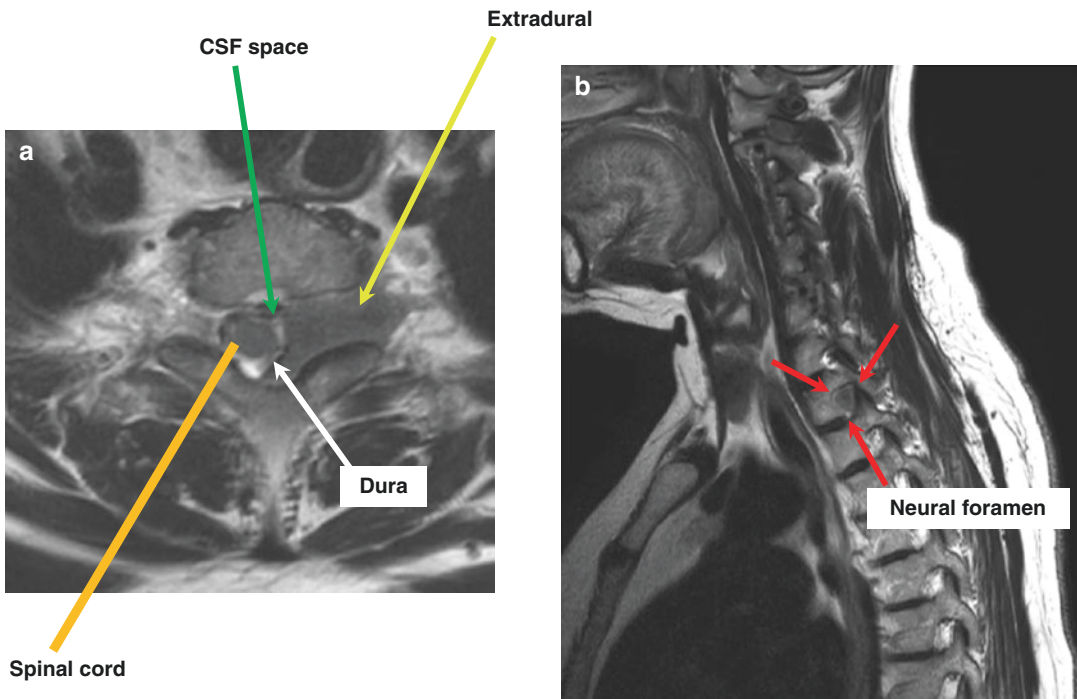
An approximately 2 cm extradural mass encasing the left T1 nerve root in a 58-year-old female. The axial T2-weighted image (a) shows extrinsic dural sac compression (*white arrow*) and tumor extension to the neural foramen (*yellow arrow*). The subarachnoid
